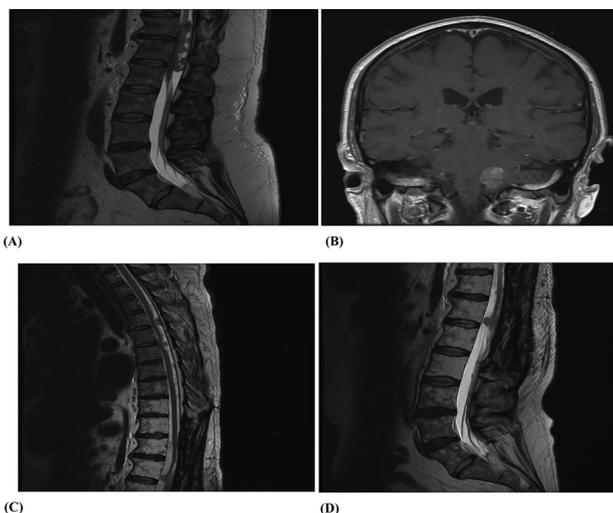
T2 weighted MR images showing (A) Primary intradural tumor extending from T11-L1 with cord compression and stenosis (B) Metastasis to the cerebellopontine angle (C) Recurrent intradural thoracic spine metastases (D) Recurrent intradural lumbar spine metastases.
